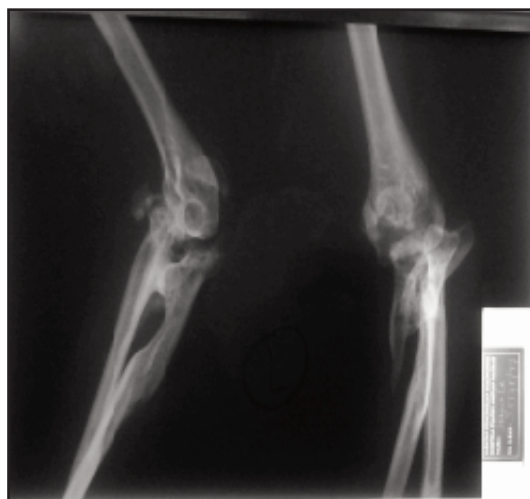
Radiographs of the patient’s left elbow showing dislocated elbow with malunion of olecranon and radial head with synostosis of proximal ulna.
